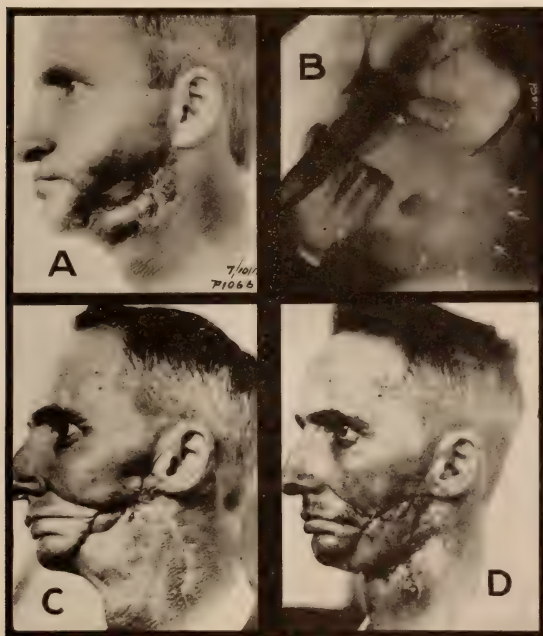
Extensive squamous cell carcinoma involving the cheek and the upper and lower jaw, with metastasis to the neck and with almost complete destruction of the lower jaw. A, the disease was destroyed June, 1915, by electrothermic coagulation, together with the removal of the metastatic glands in the neck and resection of the jaw done by Dr. Laplace. B, the wound with a healthy granulating appearance one month later. C, the wound almost closed, June, 1916. D, after a plastic operation by Dr. Laplace, June, 1916. May 15, 1917, the patient is still well and able to follow his occupation as a traveling salesman. The operations were followed by deep roentgentherapy.
